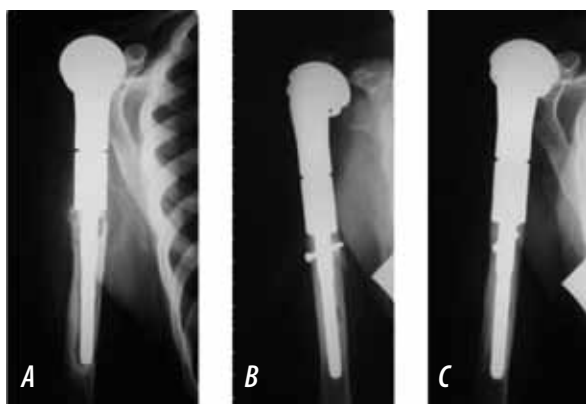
A — photoprint of the radiograph of the patient S. — aseptic loosening of the stem of endoprosthesis of the shoulder joint, produced by Inmed; B, C — photoprints of radiographs of the patient S. — a state after repeated endoprosthesis replacement of the shoulder joint with the installation of a anti-rotation screw
